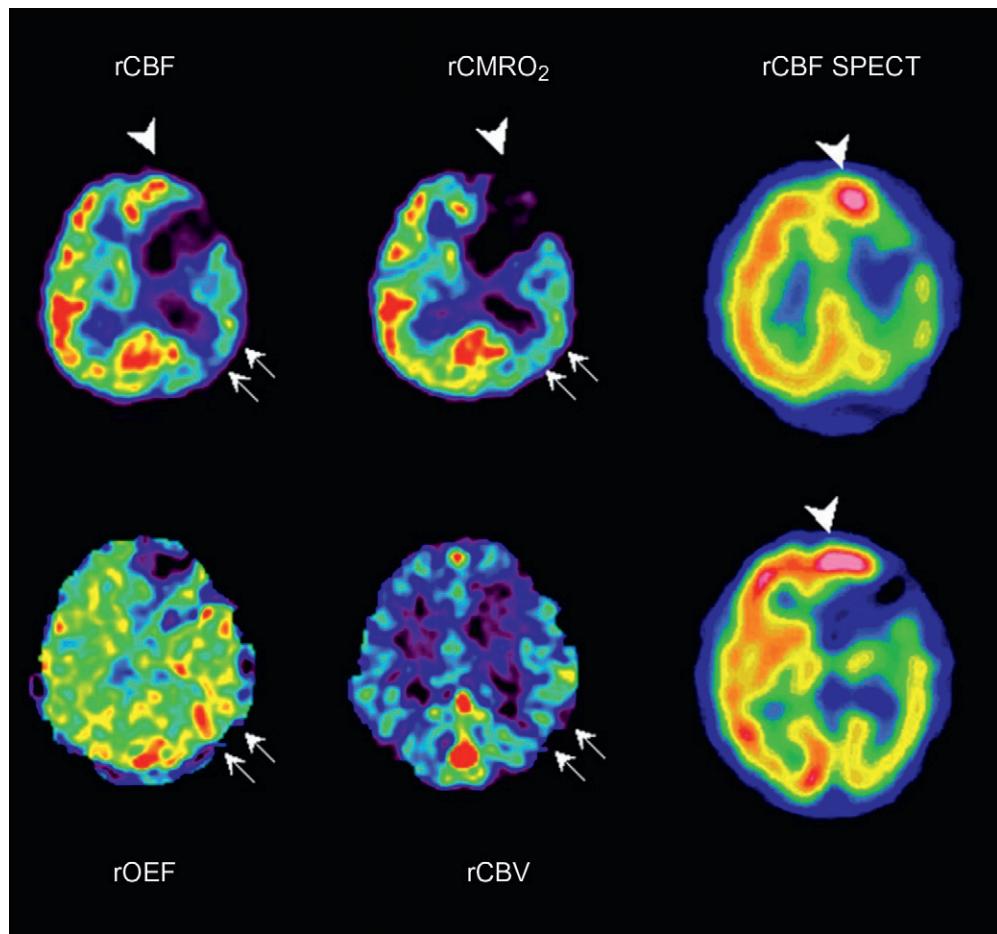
Subacute left hemispheric stroke due to left internal carotid occlusion. Oxygen-15 gas PET study (left and center columns) clearly demonstrates luxury perfusion in the left frontal cortex (arrowhead). Perfusion SPECT using ^{99m}Tc -HMPAO (right column) demonstrates hyperperfusion and hyperfixation in the same region (arrowhead). Misery perfusion is also seen in the left temporo-occipital region (small arrows). Original image taken from Oku et al. (2010) with permission from Springer.
